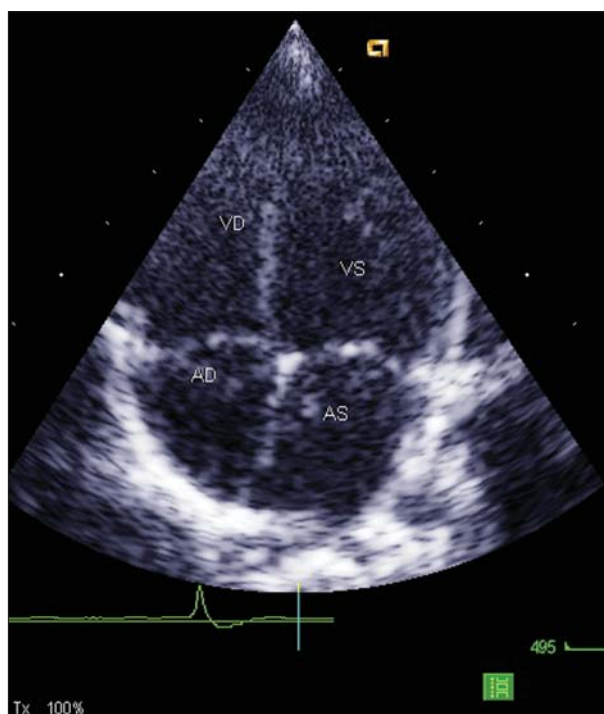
Echocardiogram performed in the eighth month showing that the tumor had completely regressed
